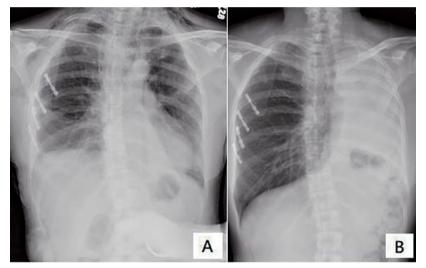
Patient's chest X-ray. (A). November 2018. (B). January 2019.
